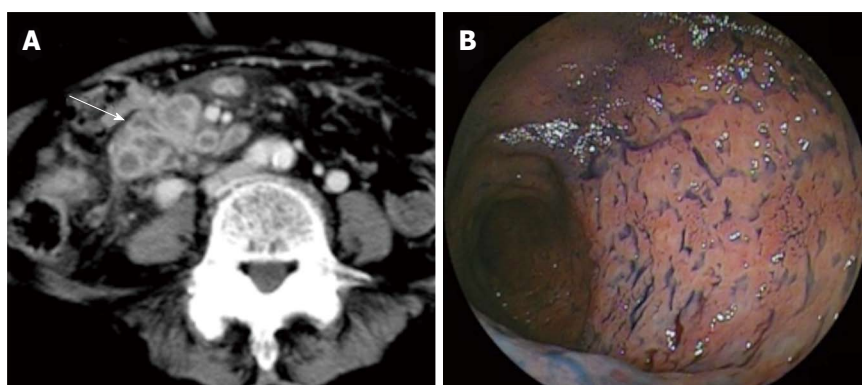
Intestinal tuberculosis is also revealed by double-balloon enteroscopy. A: Computed tomography showed wall thickening of the ileum with contrast enhancement (arrow); B: Double-balloon enteroscopy showed destruction of the small intestinal villi.
